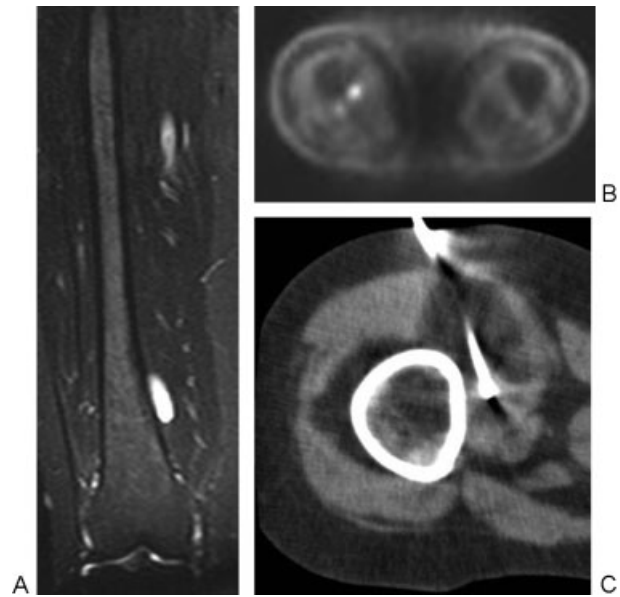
A 45-year-old with neurofibromatosis type 1 and new painful medial thigh neurofibroma (NF). (A) Coronal contrast-enhanced MRI shows NF enhancement. (B) PET/CT reveals FDG avid uptake in the lesion. (C) Biopsy results were benign, but the patient opted cryoablation for symptomatic control. CT scan performed during the procedure with ice ball formation at NF site. The patient's pain resolved posttreatment, and has now been symptom free for 3 years. CT, computed tomography; FDG, fluorodeoxyglucose; PET, positron emission tomography.
